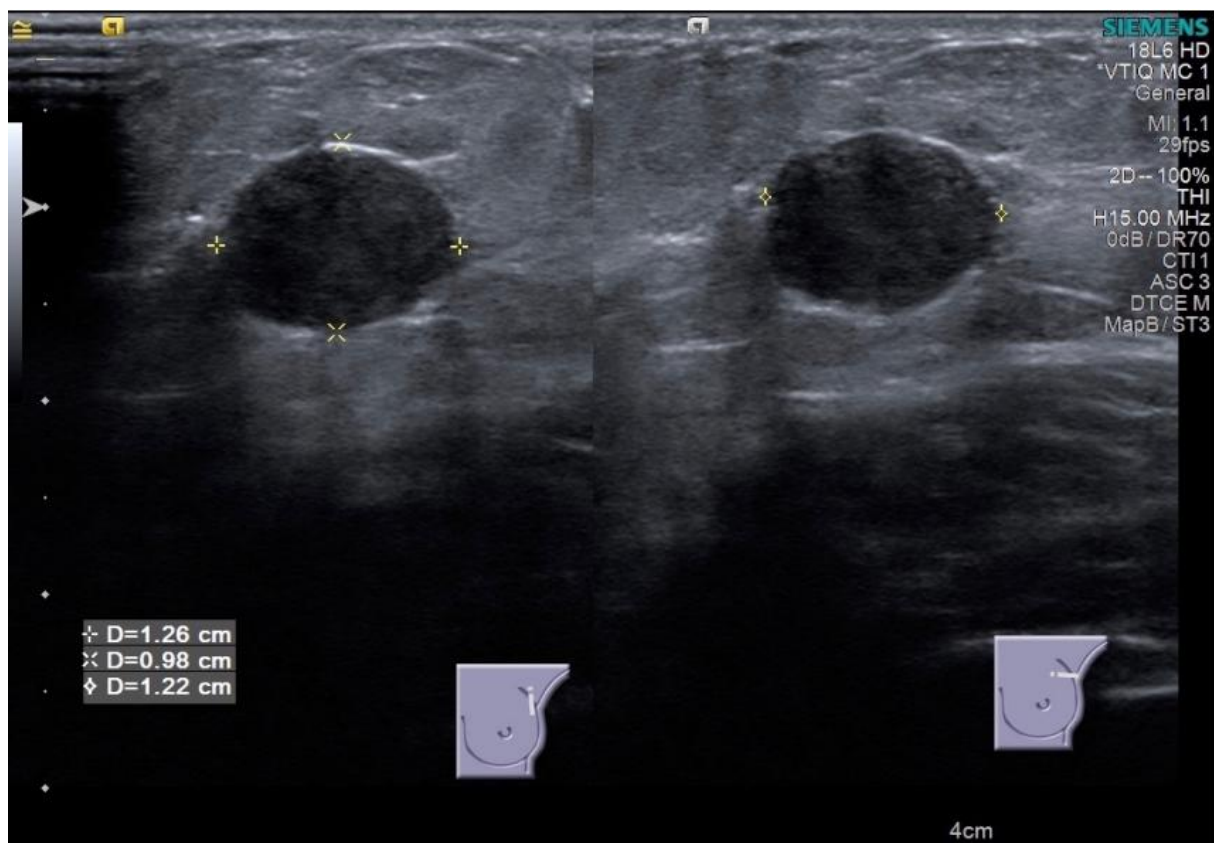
Ultrasound study revealed a hypoechoic nodular, with regular borders lesion and slight posterior acoustic enhancement, with 13 mm, on upper outer quadrant of the left breast.
